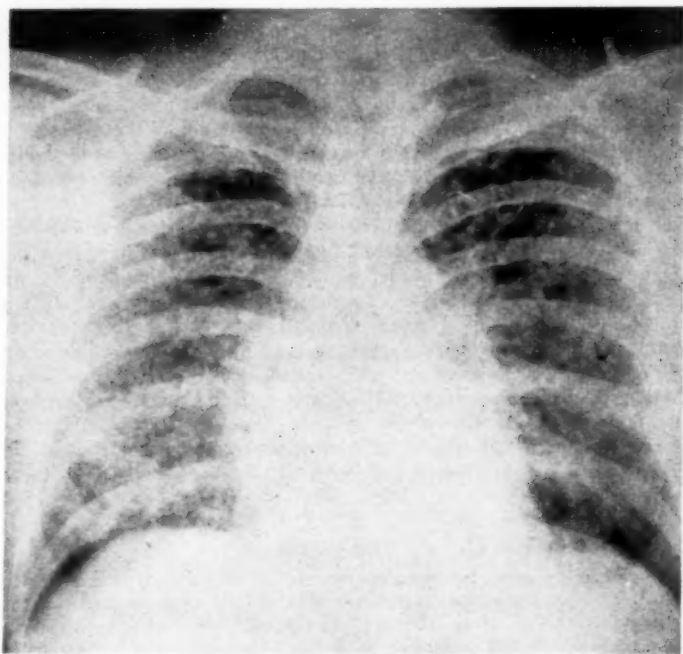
Preemployment chest roentgen-ray. Patient asymptomatic. Extensive pulmonary infiltration and hilar thickening. Heart not enlarged.
